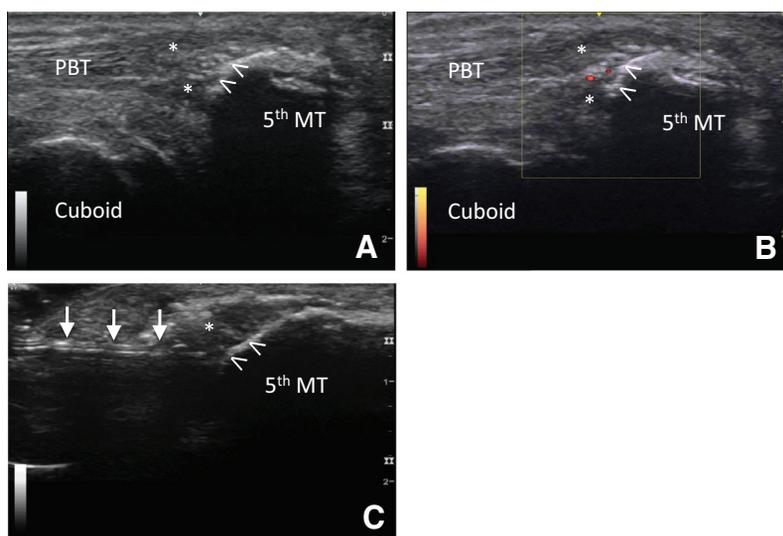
(A) Longitudinal ultrasound of the peroneal brevis tendon (PBT) showing hypoechoic thickening of the tendon (*) and irregularity of cortex (arrowheads). (B) There is 2+ neovascularity on power Doppler imaging (modified Ohberg score). (C) Ultrasound-guided percutaneous ultrasonic needle tenotomy showing the Tenex needle (arrows) entering the abnormal appearing footprint (arrowheads) and adjacent peroneal brevis tendon (*). Acoustic shadowing from the 18-gauge needle and reverberation artifact from the movement of the Tenex device distorts the image. The cuboid and base of the fifth metatarsal (MT) serve as bony acoustic landmarks.
